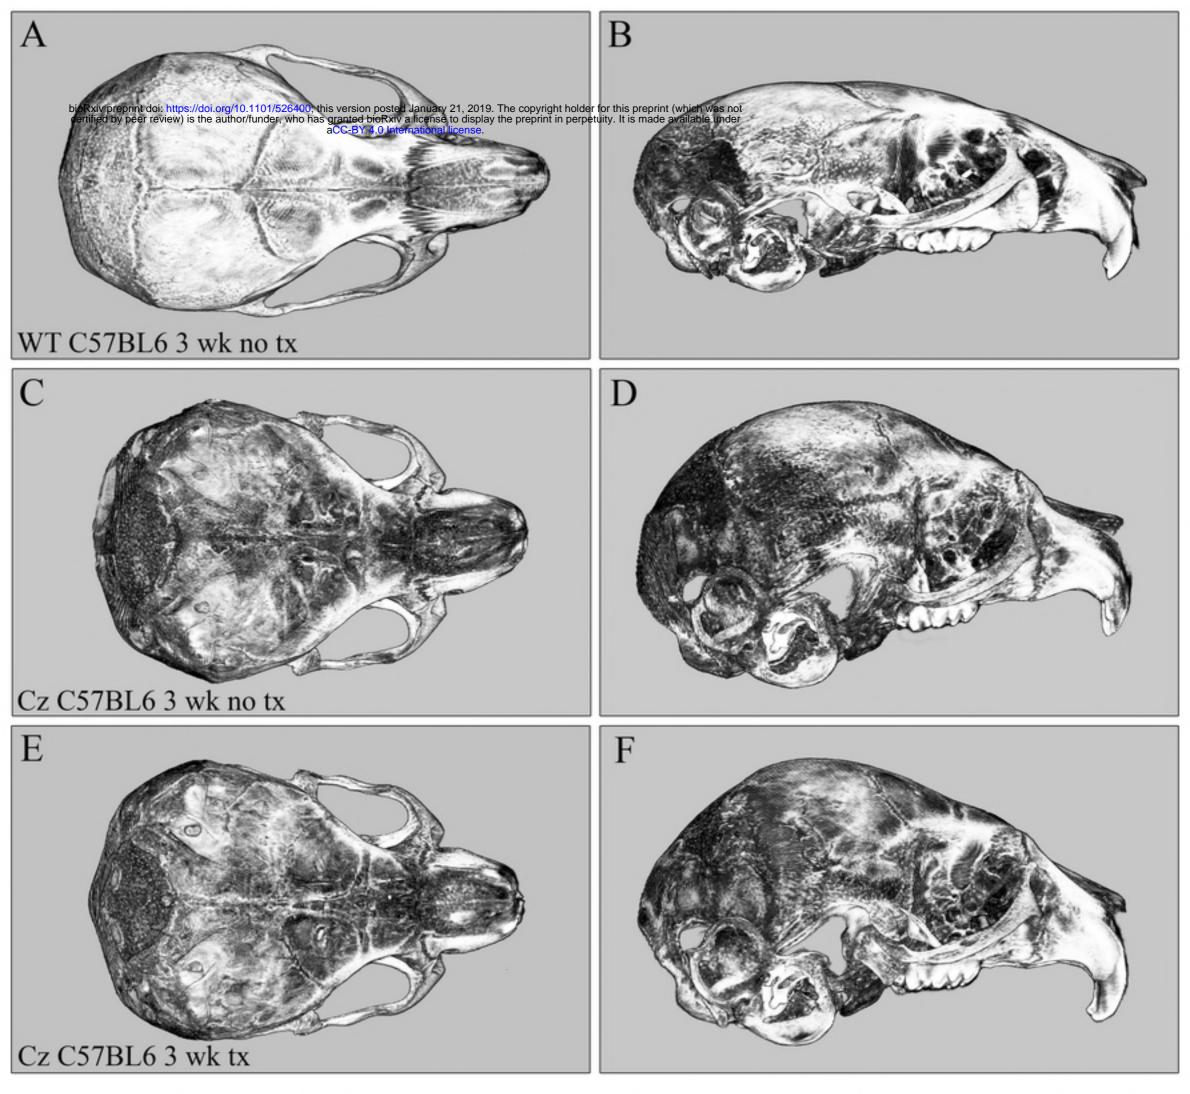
Micro CT images of C57BL/6 congenic untreated and tr
